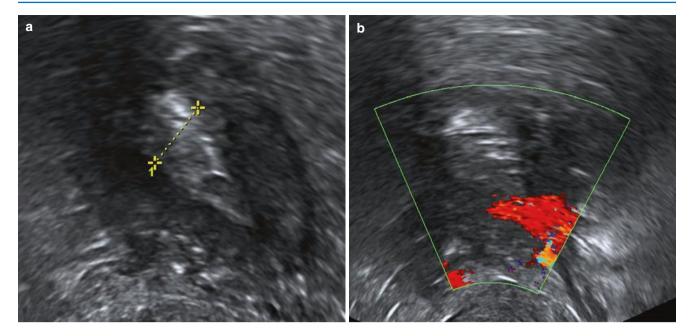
A 73-year-old patient with obesity and the first episode of postmenopausal bleeding. (a, b) Visualisation is suboptimal both on greyscale and Doppler. Endometrial thickness was 1.5 cm. On ultrasound, the only finding in a postmenopausal patient with endometrial carcinoma may be a thickened endometrium as in this case. *HPE:* endometrioid adenocarcinoma
